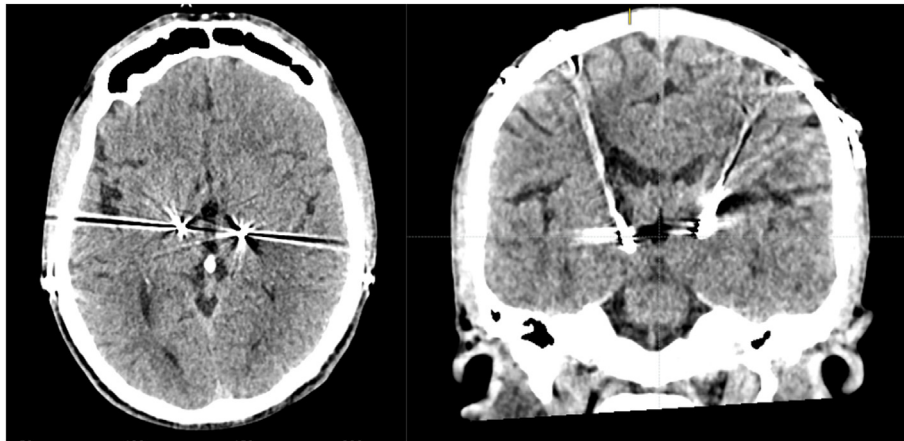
Postoperative brain CT (axial and coronal section) with final lead positioning.
